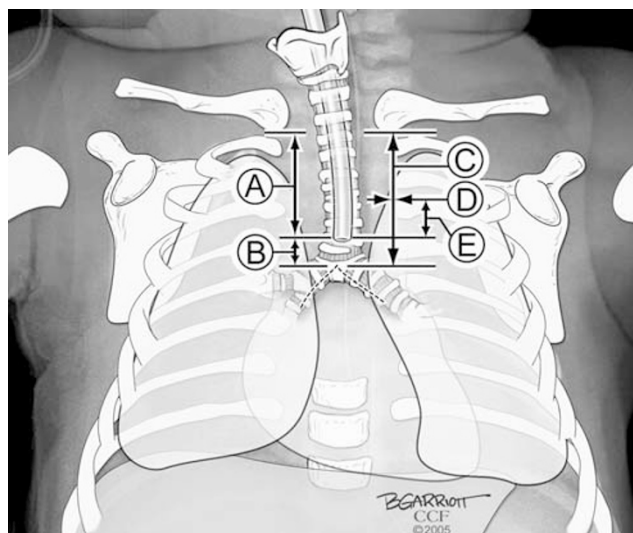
Measured and calculated distances obtained from a sample chest radiograph following endotracheal intubation. Measured distances included: the tip of the endotracheal tube (ETT) to the inferior portion of the clavicle (A) and the tip of the ETT to the carina (B). Calculated distances included: the inferior portion of the clavicle to the carina (C), the midtracheal position (D), and error between initial vs ideal ETT positions (E).
